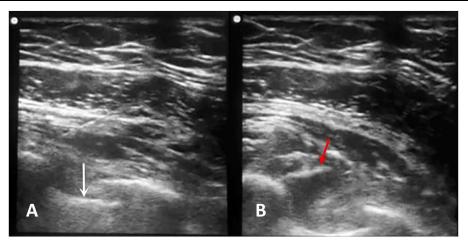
The subserratus block technique. (A) Sonographic anatomy of the layers encountered during the subserratus block showing the pleura (white arrow). (B) The local anesthetic injected to the plane between intercostal muscles and the serratus anterior muscle (red arrow).
